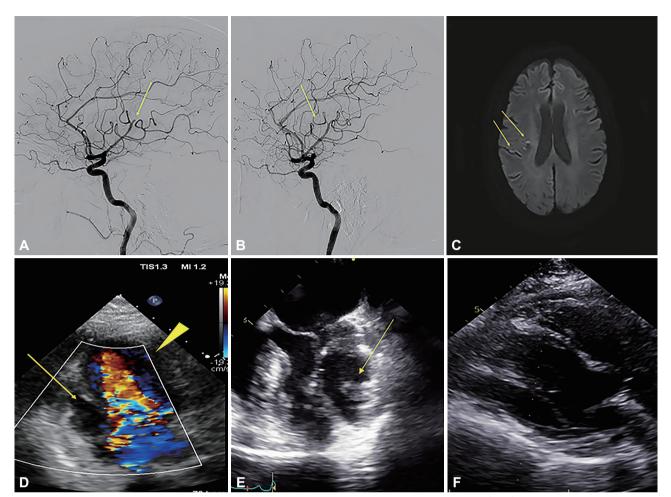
Radiologic findings of the patient. A: Occlusion in the M2 segment of the right middle cerebral artery (MCA) confirmed on digital subtraction angiography. B: Recanalization of the occlusion in the M2 segment of the right MCA using mechanical thrombectomy. C: Multiple tiny scattered right parietal-temporal lesions on diffusion-weighted imaging. D: Color Doppler imaging reveals turbulent systolic and diastolic flow in the primary (arrowhead) and secondary (arrow) chamber. E: Transesophageal echocardiography reveals a clear double-chamber left ventricle with echogenic material in the accessory cavity. F: Follow-up transthoracic echocardiography after 3 weeks of anticoagulation treatment reveals that the thrombus has disappeared.
